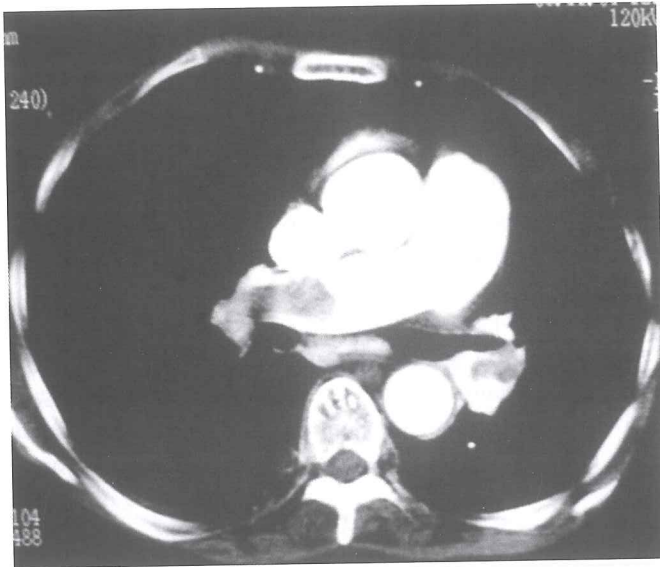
In a patient with acute pulmonary embolism, spiral CT angiography showing the right main pulmonary artery and the pulmonary artery of the left lower lobe obstructed by a thrombus.
